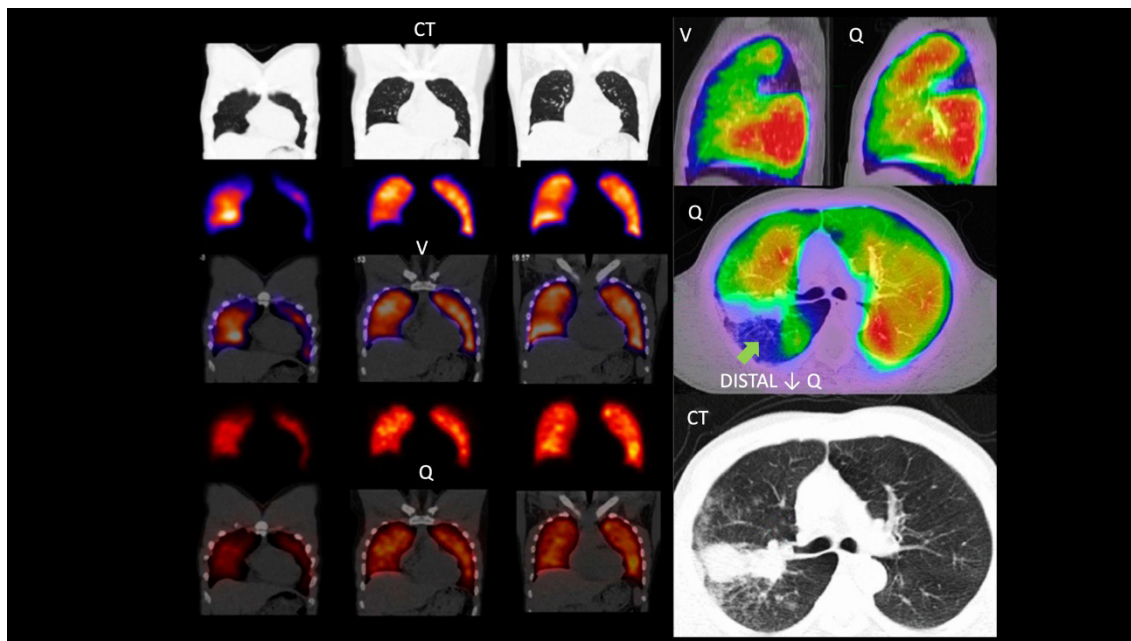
On the left, a series of images showing a normal V/Q SPECT/CT scintigram with ^{99m}Tc -labeled Technegas/MAA; from top to bottom: low-dose CT; ventilation SPECT; fused ventilation/CT; perfusion SPECT; and fused perfusion/CT. On the right, a series of images showing a V/Q PET/CT scan with ^{68}Ga -labeled Galligas/MAA; from top to bottom: sagittal views of fused ventilation/CT (left) and perfusion/CT (right); matched defect, fused PET/CT perfusion image showing a perfusion defect (arrow); and a CT image showing a tumor obstructing the bronchus, corresponding to the ventilation/perfusion defect on PET imaging. Adapted from Le Roux PY et al.²⁷⁹ and Bailey DL et al.²⁸⁰
